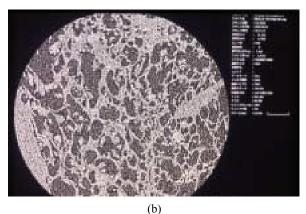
Micro CT images of the abnormal lung tissue. (peripheral type of lung adenocarcinoma) (a) Resolution: $24 \mu m$. (b) Resolution: $6 \mu m$.
